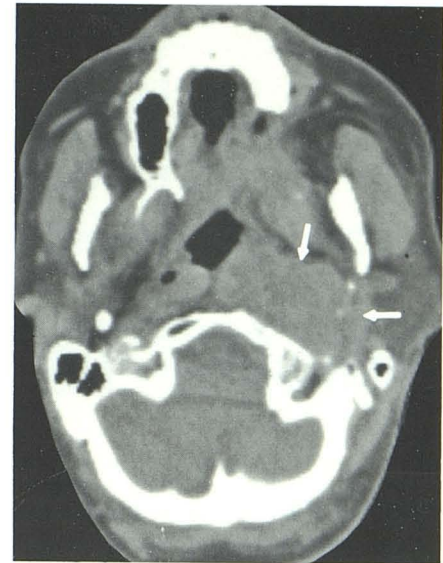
65-year-old man with left vocal cord paralysis. Physical examination was otherwise normal. Large, entirely submucosal squamous cell carcinoma in nasopharynx (arrows). Confirmed by CT-guided biopsy.
